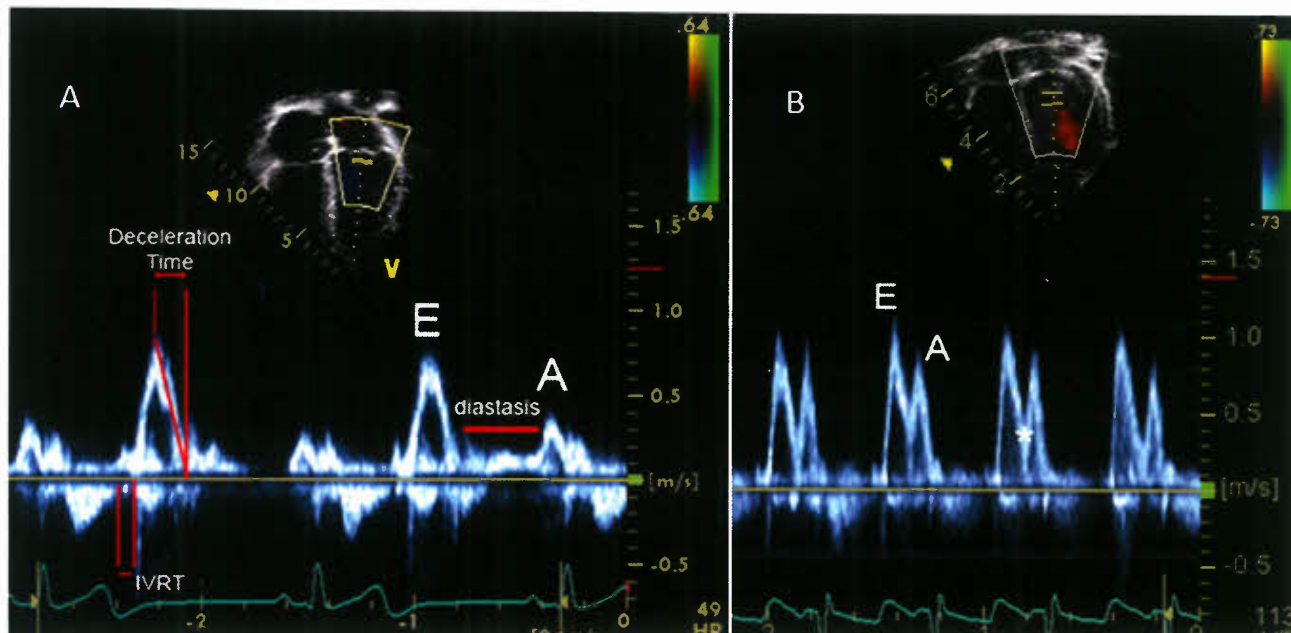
Mitral inflow at slow heart rate (panel A): Pulsed Doppler of the mitral inflow. The cursor is positioned at the tips of the mitral leaflets. Early (E) and late (A) diastolic waves are seen. Minimal flow is seen in diastasis—the period between the E and A waves. The isovolumic relaxation time (IVRT), measured from cessation of LV outflow to onset of mitral inflow and E-wave deceleration time (DT) are depicted. Mitral inflow at fast heart rate (panel B). Doppler of mitral inflow. Due to the fast heart rate, there is no diastasis and the E and A waves begin to overlap. At higher heart rates, these will merge into a single inflow wave. The asterisks depicts the “E at A” point. This is the point where the E and A waves merge when the E wave does not reach the baseline.
